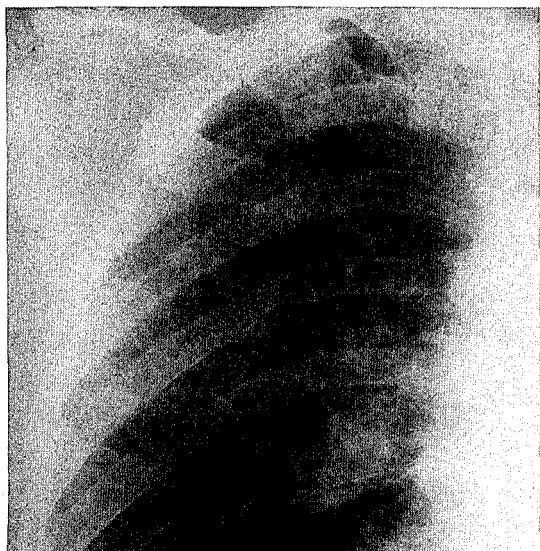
Close-up view of the chest radiograph in the episode of recurrence, the diffuse reticulonodular lesions were similar to the pictures disclosed in the first hospitalization (Figure 1).
